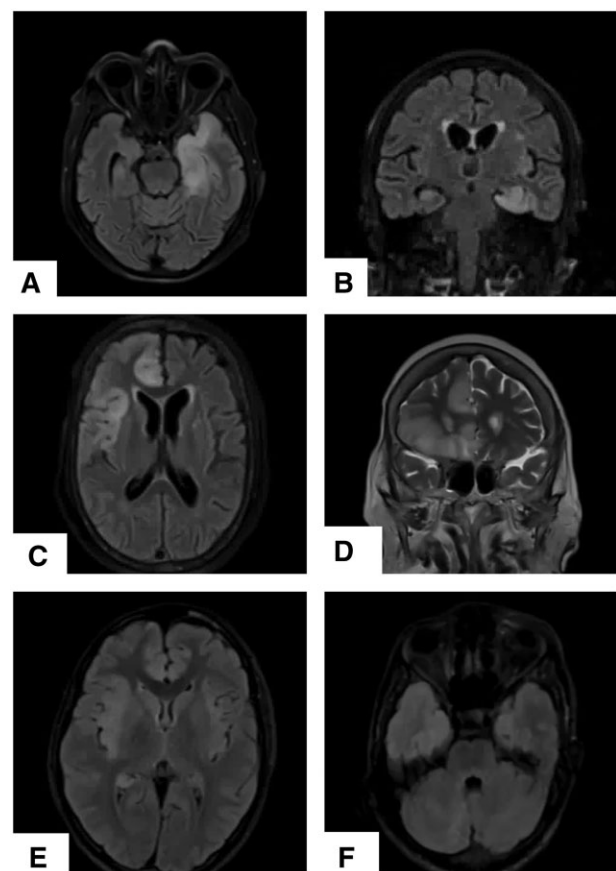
MRI brain T2FLAIR sequence revealing asymmetric medial temporal hyperintensities (left>right) (A). T2FLAIR hyperintensities visible in bilateral medial temporal regions (left>right) (B), right medial frontal and insular cortex (C) and right medial frontal and orbitofrontal regions (D). T2FLAIR hyperintensities noted in bilateral medial frontal and insula (E) and bilateral medial and anterior temporal regions (right>left) (F).
